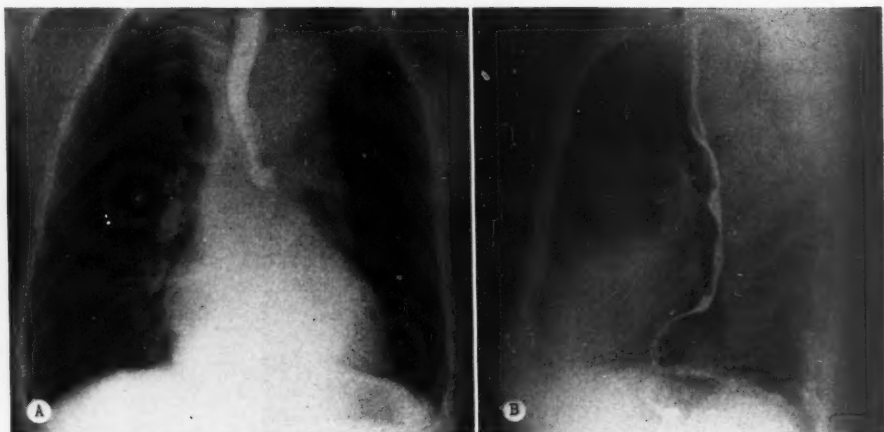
Chest roentgenogram showing further increase in width and tortuosity of aorta and marked distortion of esophagus by extrinsic pressure. Diaphragm has returned to normal level. A. Posteroanterior projection. B. Lateral projection.
